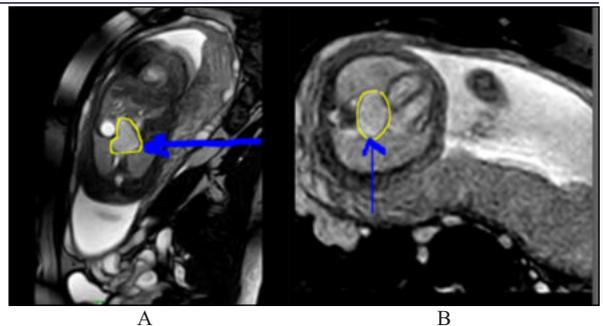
Fetal MRI : A- Well defined T 2 Hyperintense lesion seen just below the diaphragm (marked by yellow line).
